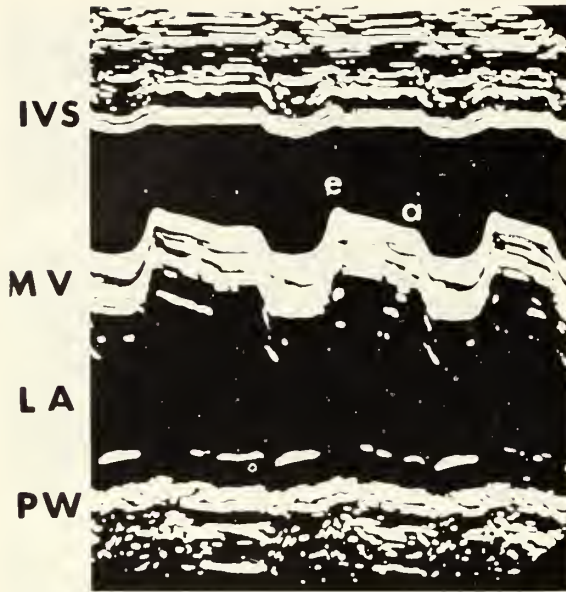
Echocardiogram of a patient with moderately severe mitral stenosis in whom the amplitude of valve motion (arrow) is much greater than in Figure 4. This suggests valvotomy will probably be possible.
